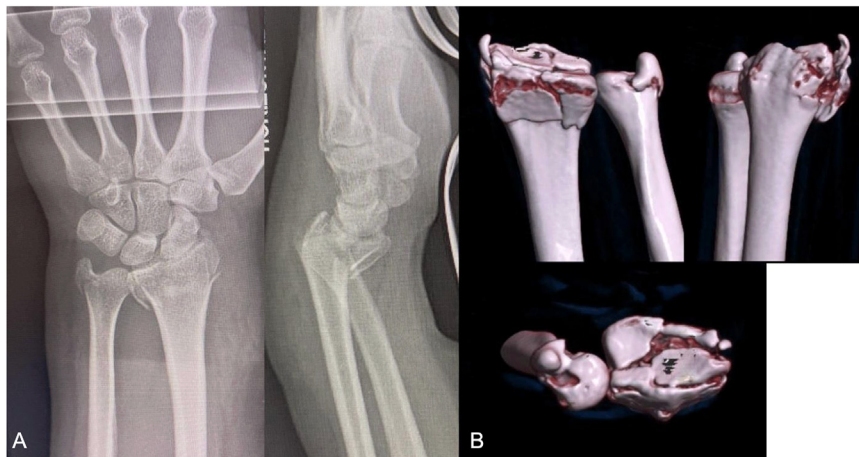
(A) Radiograph (anteroposterior and lateral views) showing an intra-articular distal radius fracture of the left wrist with central die-punch and volar shear fragments. (B) The degree of articular involvement can be better appreciated on computed tomography. The axial cuts provide valuable details about the articular surface, including the pattern and degree of displacement.
